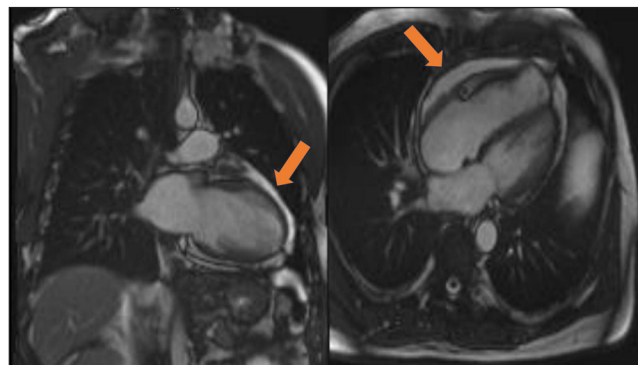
Cardiac magnetic resonance images showed pericardial thickening and calcification.
